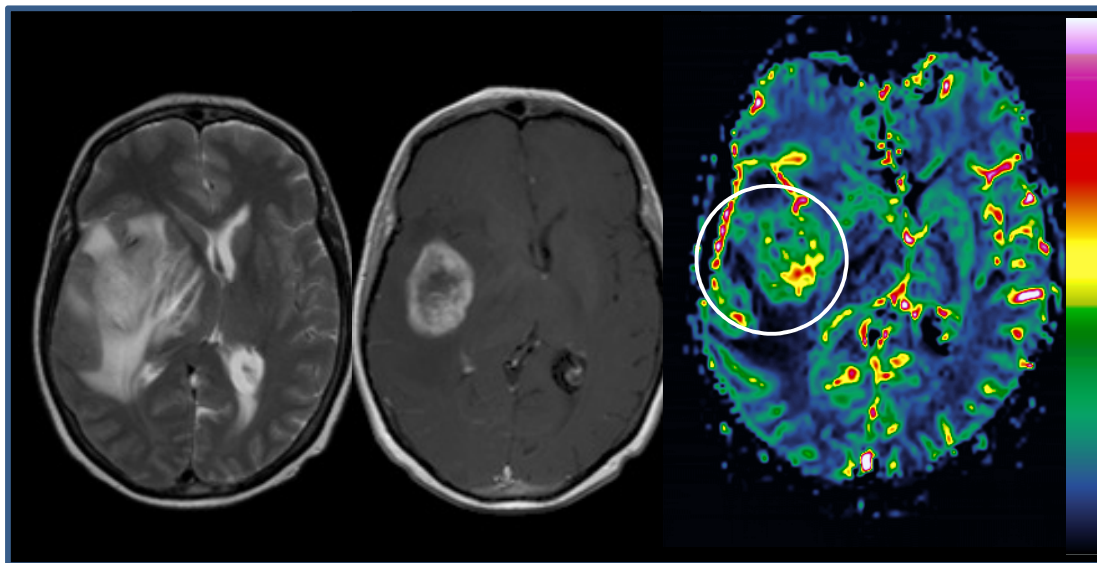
DSC imaging in a patient with a high grade glioma. The tumor (including aedema) is clearly visible on T2-weighted image (left) with strong contrast enhancement evident on T1-w image after gadolinium administration (centre). The corresponding BV map shows a distinct area of high blood volume in one region of the tumor which corresponds to the most malignant area of the tumor.
